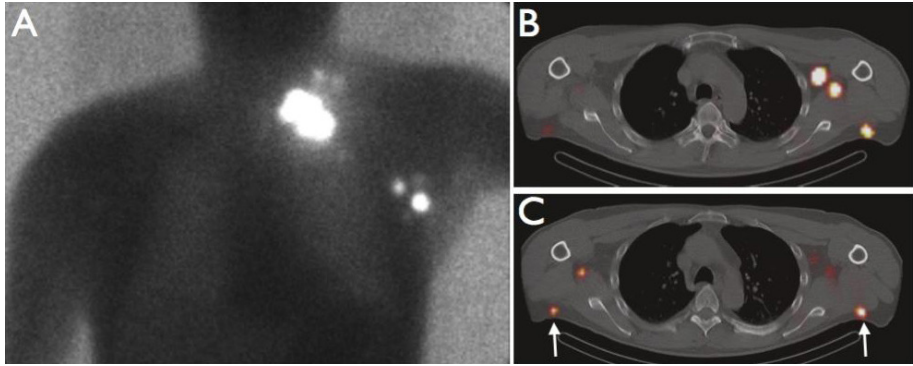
Planar anterior image (A) showing radiocolloid drainage from the injection site to the left supraclavicular area and to the left axilla in a patient with melanoma of the upper back. Axial fused SPECT/CT images (B, C) showing additional LNs in both periscapular areas (arrows) and in the right axilla. These nodes are also considered to be SLNs.
